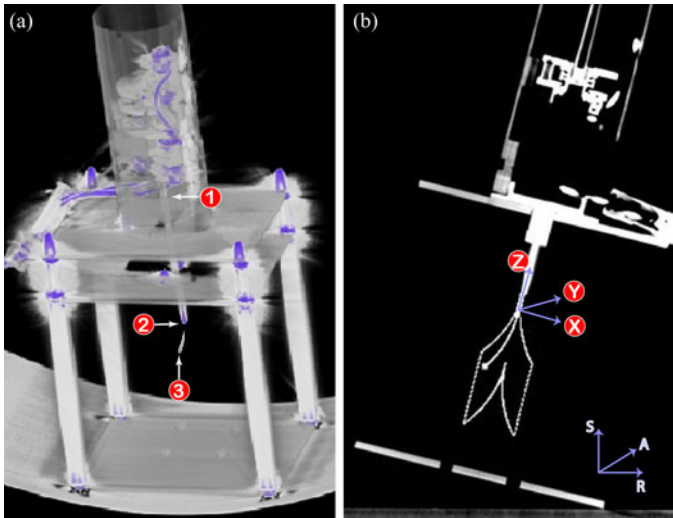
(a) Three-dimensional-reconstructed image from 2-D CT slices. The location of the three registration points on the cannula and stylet are pointed. (b) Robot is intentionally inclined with respect to the scanner CS, and the registration has adapted the feasible area, the path, and the target to execute the inverse kinematics along the correct geometry.
